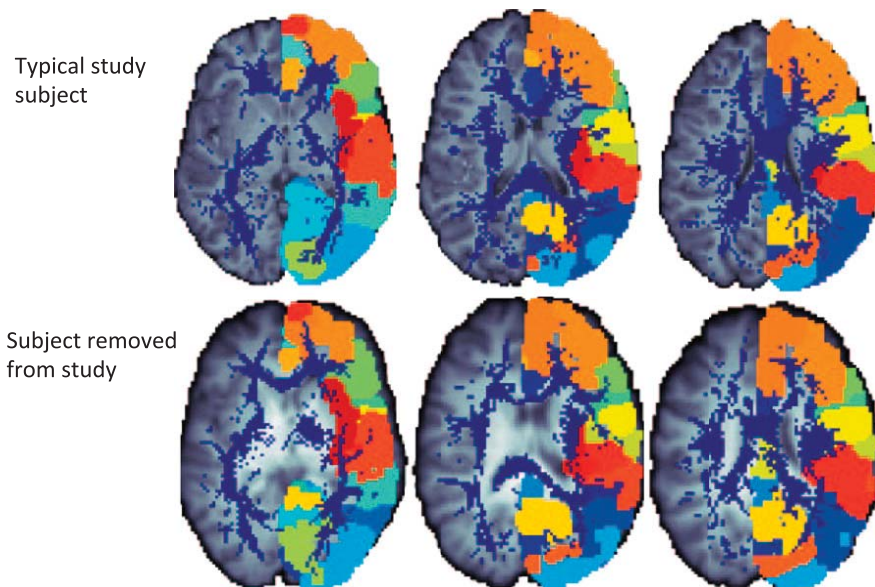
For each subject, a series of colored images is created to overlay the fiber density map, the corresponding T1-weighted image, and the dilated FreeSurfer parcellations. Examination of these images allowed us to determine which registrations were poor, resulting in subject elimination. Axial images are shown for a typical subject (*Upper*) as well as one of those subjects removed from analysis because of poor alignment and high levels of EPI distortions (*Lower*).
